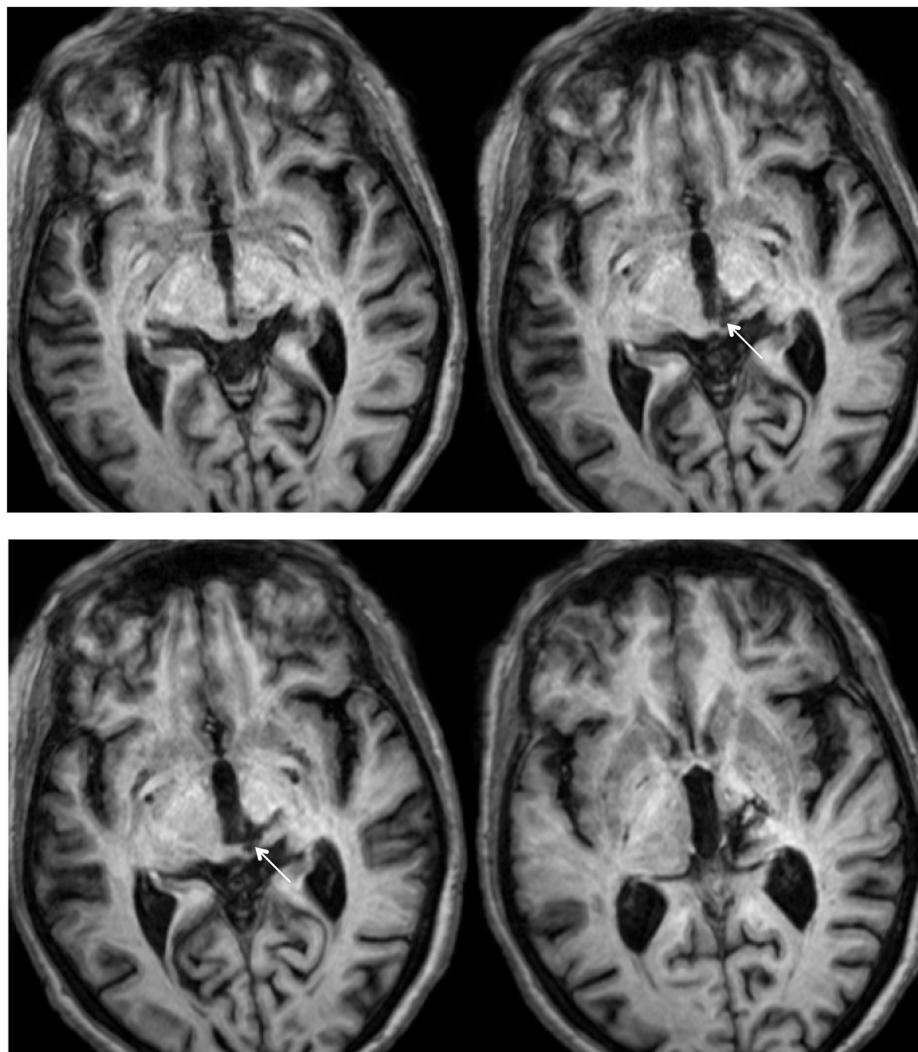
High resolution (0.7 mm^3) T1-weighted MRI of patient RE. Axial slices from ventral (Top left) to dorsal (Bottom right) showing the lesion in the right dorsal midbrain and thalamus. Extension of the lesion into the rostral superior colliculus (SC) shown by white arrows.
